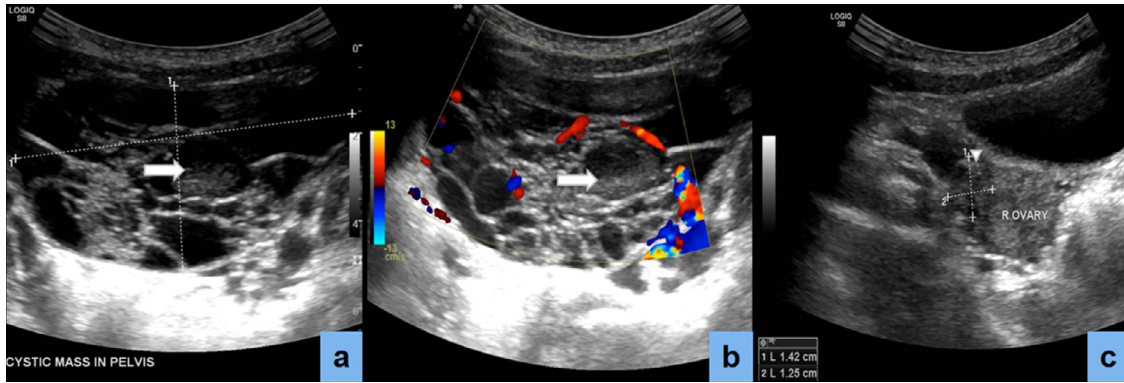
Abdominal ultrasound revealed a large, multilobulated, cystic mass of the left ovary, with numerous septations of varying thickness, forming a sponge-like shape (a). The lesion walls and septa appeared hypovascular on Doppler ultrasound (b). Several cysts presented fluid-fluid levels inside (arrows). The normal right ovary (arrowhead) was also observed on ultrasound (c).
